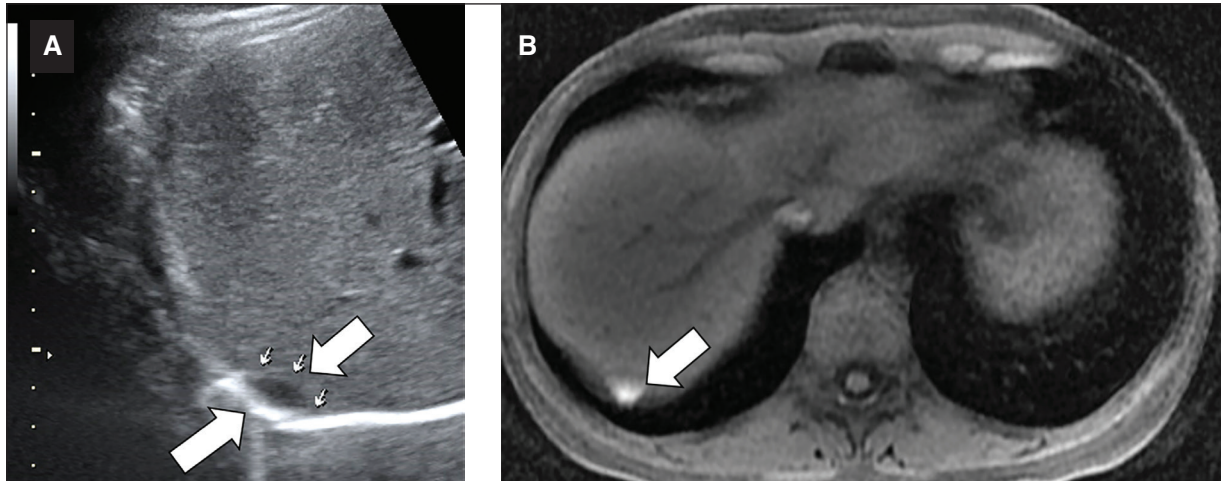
Diaphragmatic endometriosis in a 33-year-old-woman with catamenial right shoulder pain. A: abdominal US image demonstrates a hyperechoic plaque associated with cystic area (arrows) located between the diaphragm and hepatic surface. B: axial T1-weighted MRI with fat-saturation demonstrating hyperintense nodular foci located between the hepatic surface and the diaphragm representing hemorrhagic content (arrow).
